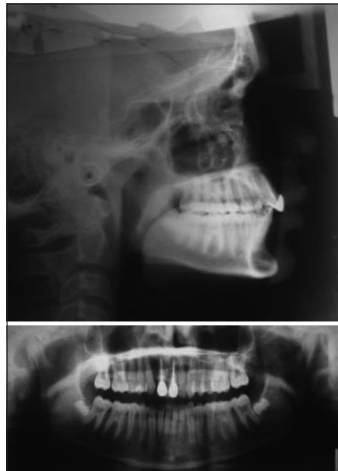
Postoperative posttreatment orthopantomogram and lateral cephalogram
